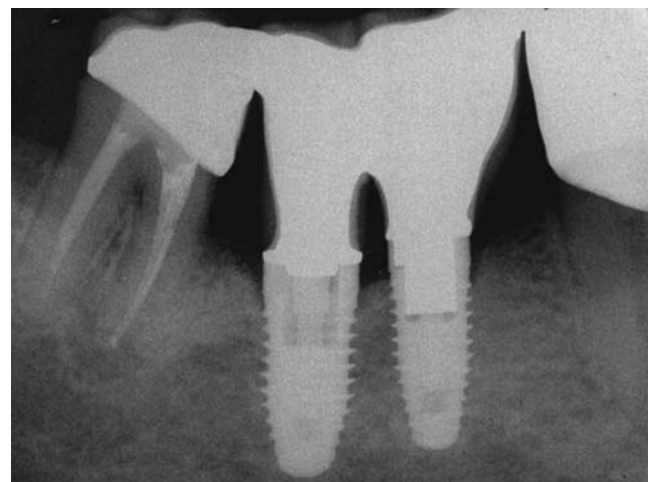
The intraoral radiograph revealed a complete fill of the intrabony defect and a significant improvement in vertical dimension of the resorbed ridge. At 2 years after insertion of the implants, a stable periimplant condition can be observed
